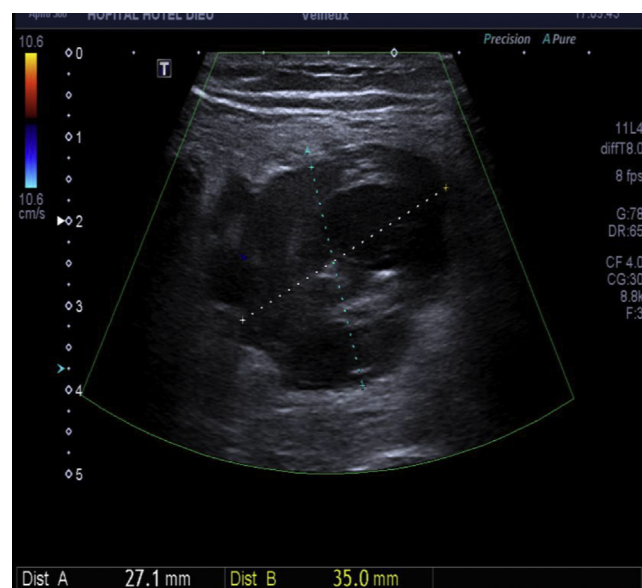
Ultrasound image of the popliteal venous aneurysm (PVA), cross-sectional view.
